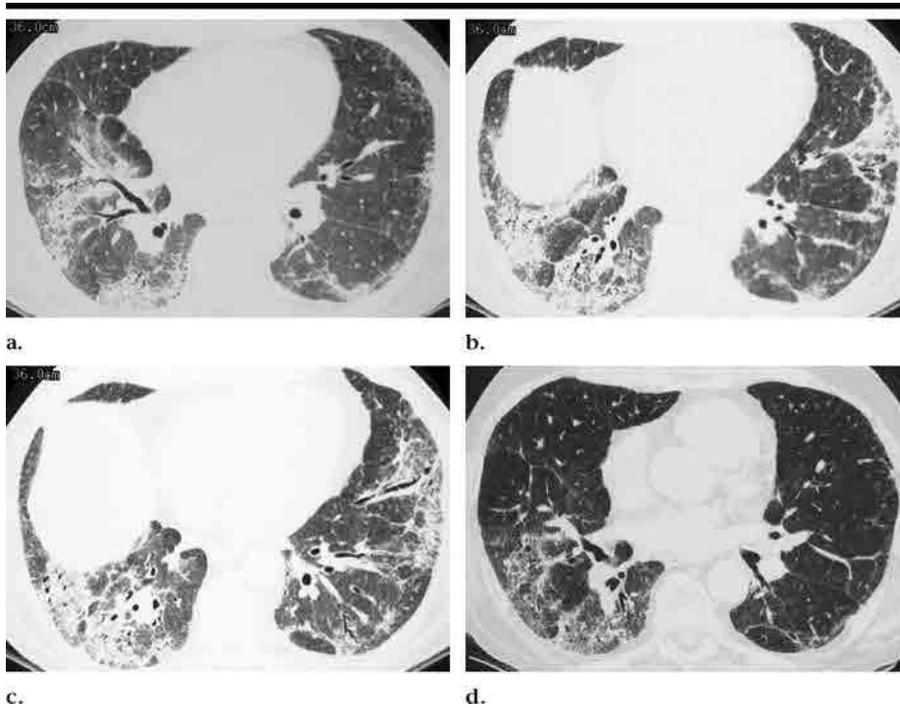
NSIP in a 62-year-old man with scleroderma. (a–c) Transverse thin-section CT images show peribronchovascular and peripheral distribution of ground-glass opacity associated with reticular pattern. Marked bilateral lower-lobe volume loss and traction bronchiectasis indicate extensive lung fibrosis. (d) Transverse thin-section CT image obtained 2 years later shows decreased ground-glass opacification but persistent reticular pattern.
